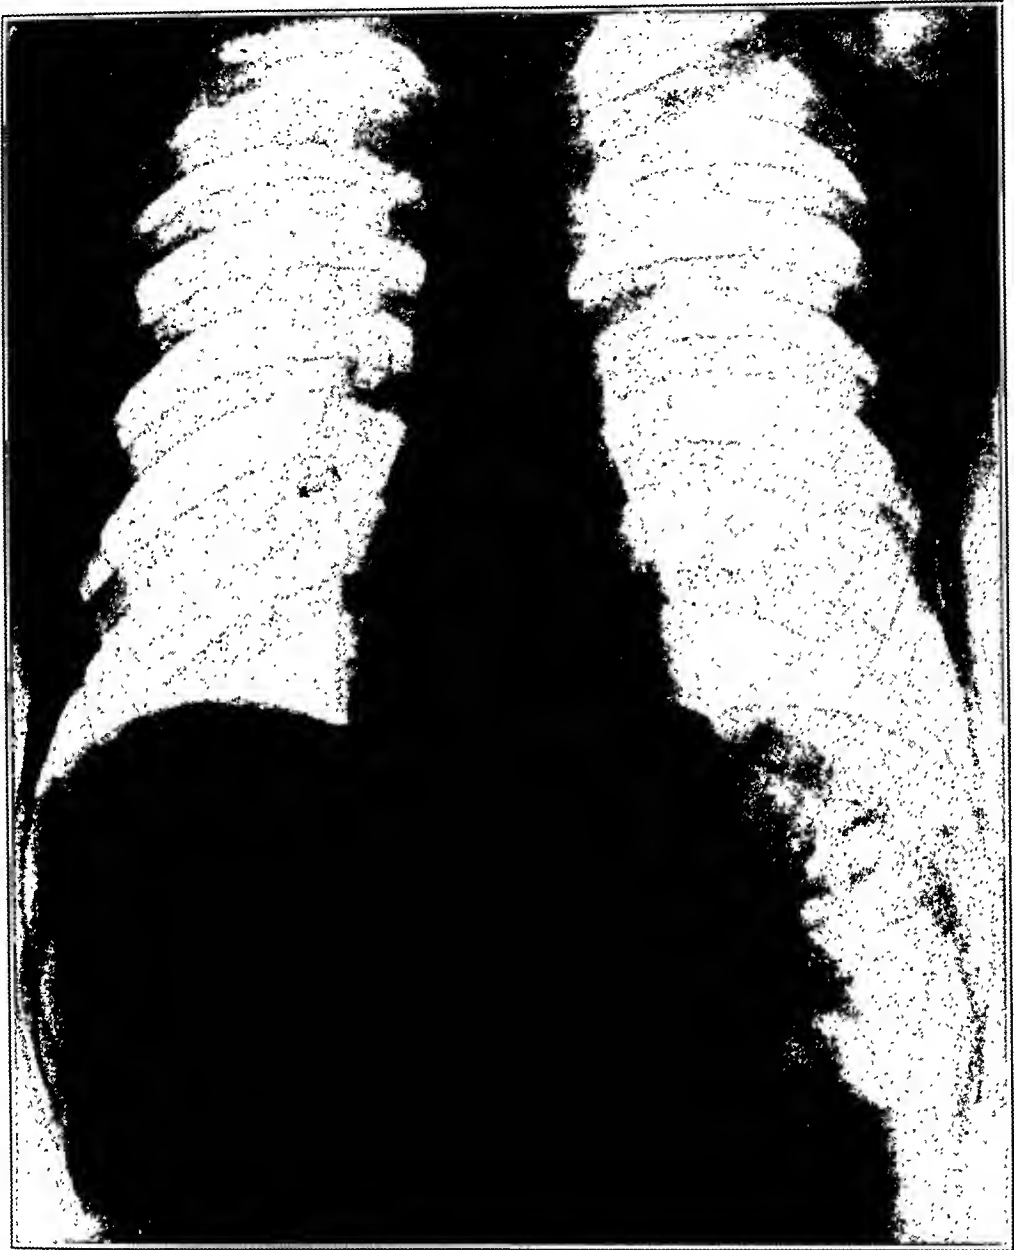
(case 15).—Appearance of the x-ray film seven days after figure 5 was taken and twelve days after perforation. The free air has been almost completely absorbed. The splenic flexure remains distended by gas.
